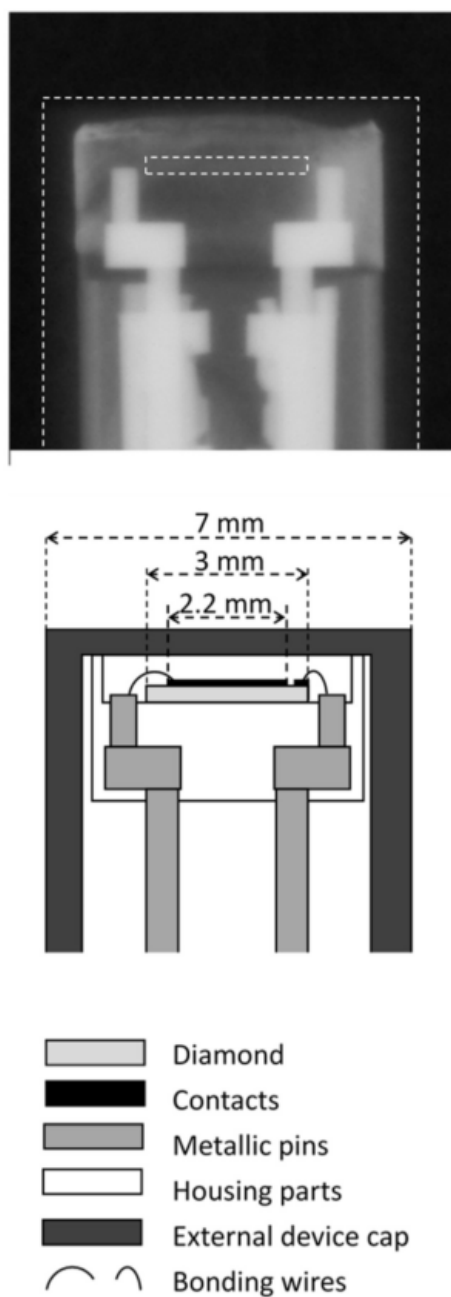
X-ray image and geometrical sketch of microDiamond detector, reproduced from Marinelli et al. 2016 [50].
